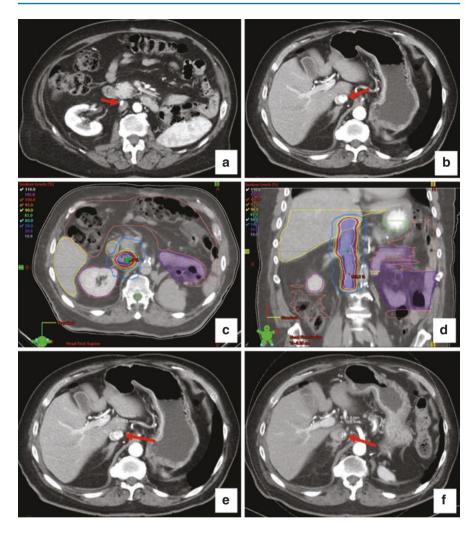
Sample images of a case of a patient with RCC IVC tumor thrombus with adherence of the tumor thrombus to the IVC wall, making resection not possible. The patient was treated with SAbR 36 Gy/3 fractions. (a, b) Axial abdominal CT with contrast, arrows highlighting arterially enhancing mass in the infra-hepatic IVC consistent with RCC recurrence. (c, d) Axial and coronal abdominal CT with radiation dose distribution as a percentage of prescription dose. Nearby organs at risk are also contoured—duodenum (yellow), right kidney (pink), liver (yellow), and bowel space (salmon). (e) Pre-SAbR tumor thrombus 1.6×2.0 cm. (f) 6-month post-SAbR tumor thrombus 1.2×1.6 cm. *IVC* inferior vena cava, *RCC* renal cell carcinoma, *SAbR* stereotactic ablative radiation therapy
